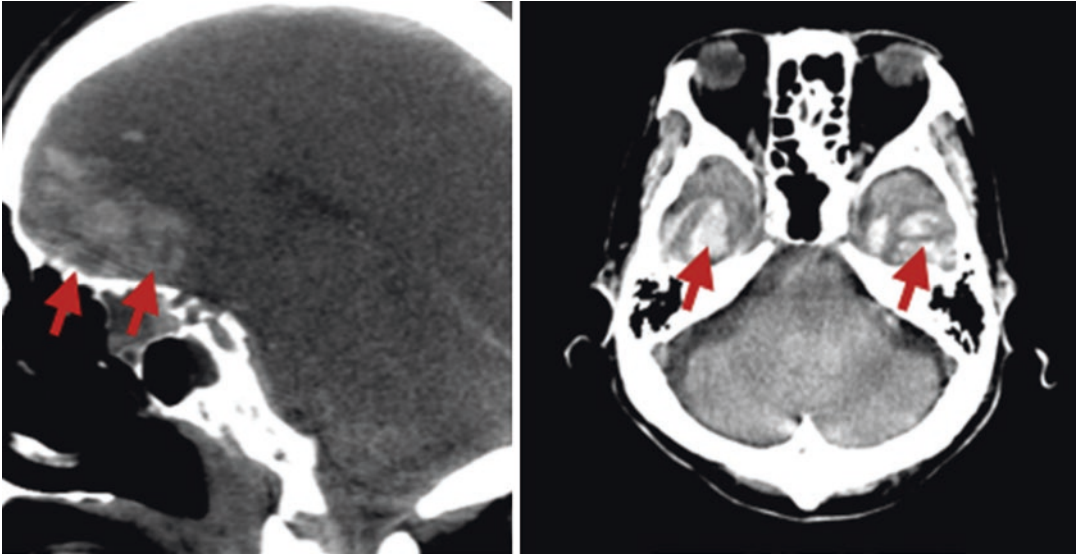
Sagittal and axial brain computed tomography images showing mixed high- and low-density masses in the inferior part of the anterior lobe and the temporal tips, highly suggestive of brain contusion
